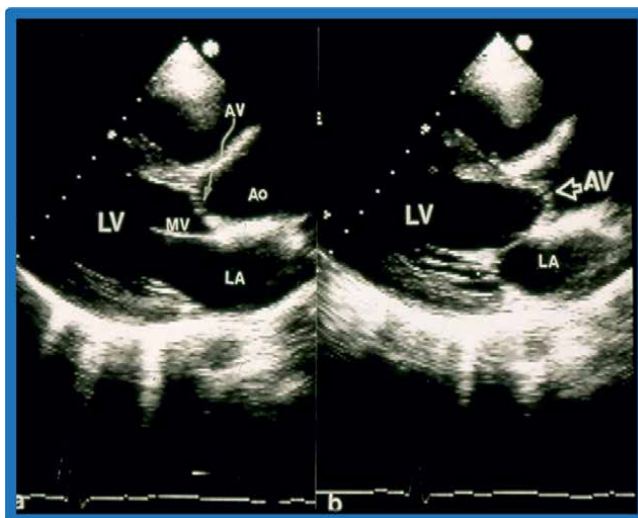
Echocardiographic frames from precordial long axis view of the left ventricle (LV) demonstrating valvar AS. Note the thickened and domed aortic valve (AV). Ao, aorta; LA, left atrium; LV, left ventricle. Reproduced from reference [17].
